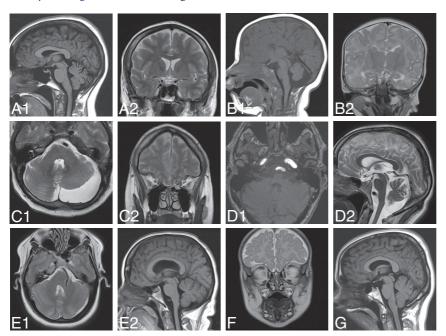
A, A 49-year-old woman with a PITX2 mutation had superior vermian volume loss on the TI-weighted sagittal image (AI) and optic chiasm thinning on the T2-weighted coronal image (A2). B, A 2-month-old girl with an unsolved mutation had inferior vermian hypoplasia and a widened tegmentovermian angle on the TI-weighted sagittal image (B1) and malrotated hippocampi on the T2-weighted coronal image (B2). C, A 43-year-old man with a FOXC1 mutation had mega cisterna magna and an ectatic basilar artery and a hypoplastic left cerebellar hemisphere on the T2-weighted axial image (C1) and hypoplastic olfactory bulbs on the T2-weighted coronal image (C2). D, A 46-year-old man with a FOXCI mutation had a tortuous basilar artery and an ectatic cavernous segment of the left ICA on axial TOF angiography (DI); a short mesencephalon with loss of the normal relationship among the mesencephalon, pons, and medulla; loss of volume in the superior vermis and ectatic basilar artery; and flow void seen end-on on the T2-weighted sagittal image (D2). E, A 41-year-old woman with a FOXC1 mutation had a tortuous basilar artery flow void on the T2-weighted axial image (E1), a short mesencephalon with loss of the normal relationship among the mesencephalon, pons, and medulla, and bowing of the corpus callosum secondary to ventriculomegaly on the TI-weighted sagittal image (E2). F, A 3-month-old boy with an unsolved mutation had absent olfactory bulbs on the T2-weighted coronal image. G, A 31-yearold woman with an unsolved mutation had a thickened splenium and tonsillar ectopia on the TIweighted sagittal image.
